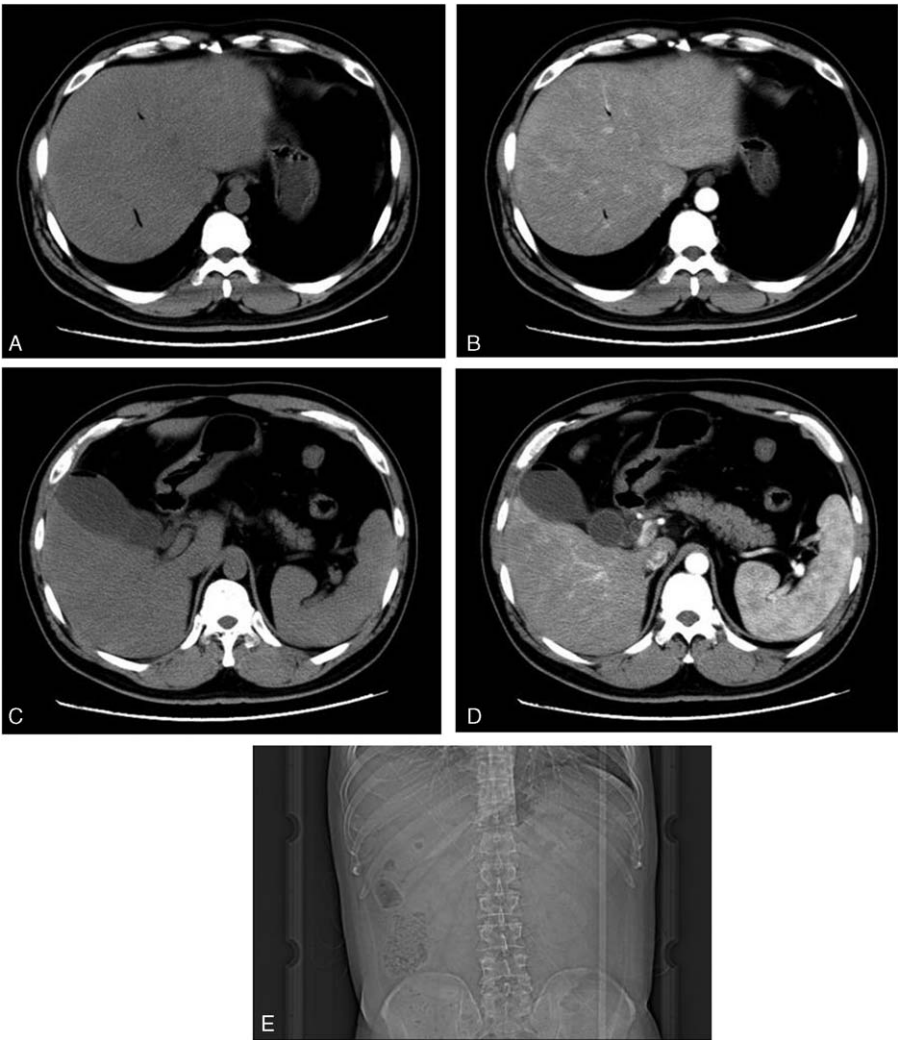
Computed tomography (CT)-scan (A-D) and plain-film radiography (E) showing air in the gallbladder wall or lumen.
